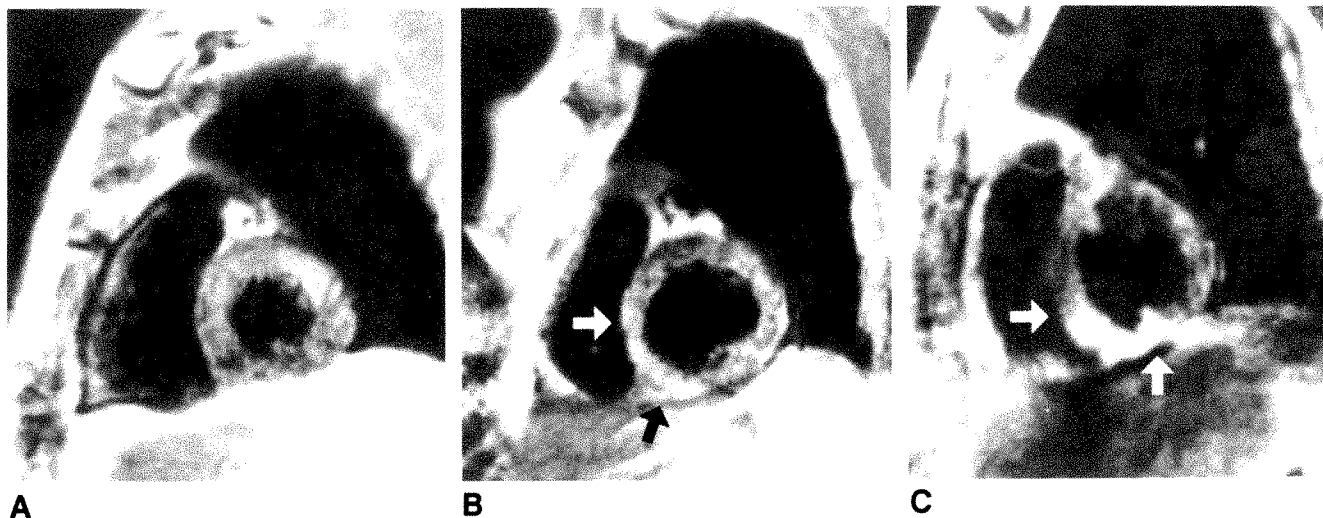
T1-weighted MR images of myocardial infarction (arrows) used in qualitative analysis of Gd-DTPA contrast enhancement. Typical patterns of no enhancement (A), moderate enhancement (B), and marked enhancement (C) are shown.
